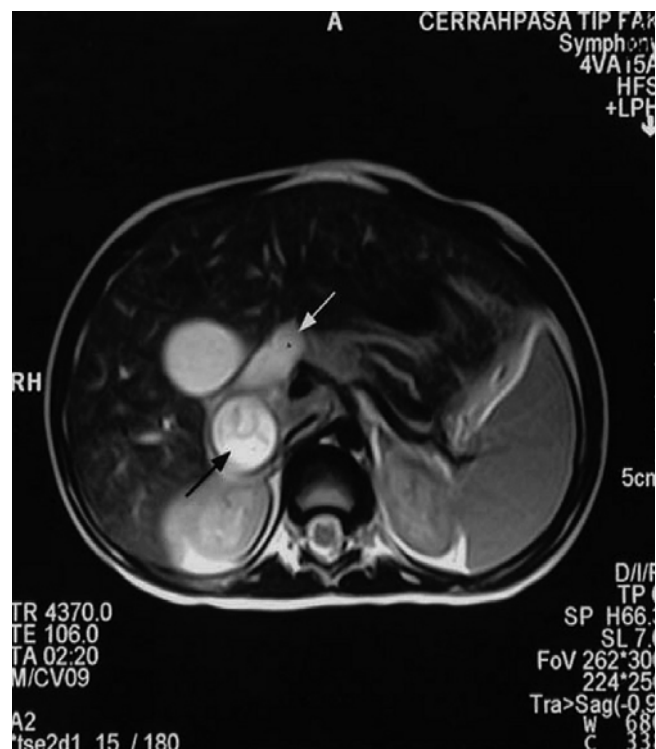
MRI of rhabdomyosarcoma of the common bile duct: *black arrow* points to mass, *white arrow* to CBD (from Tireli [145])
